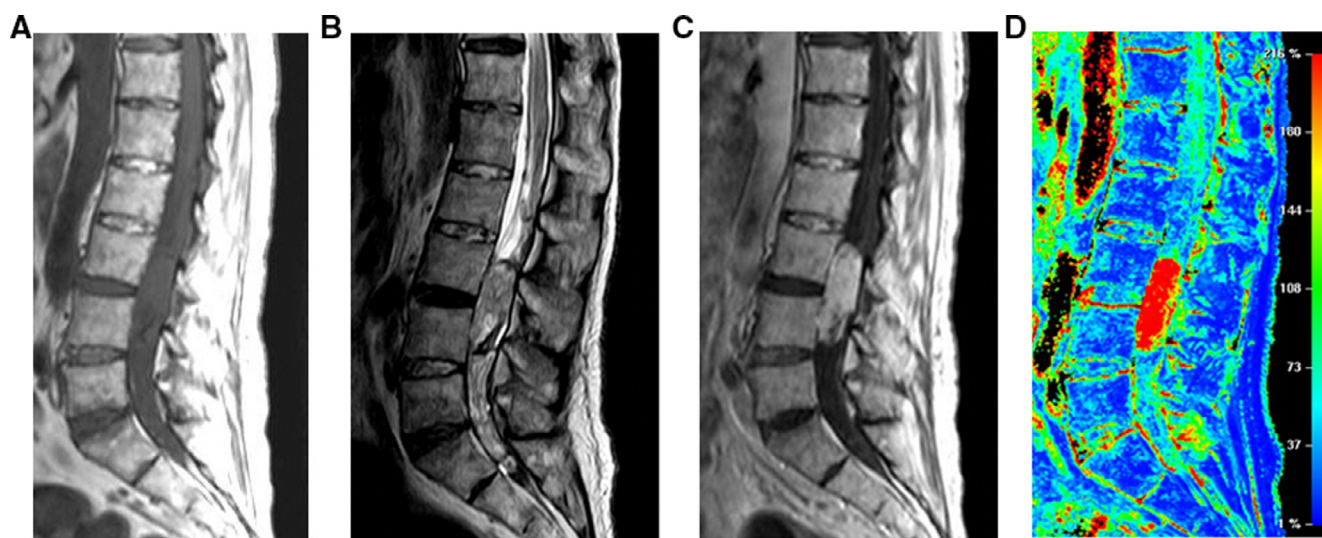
Paraganglioma of the cauda equina in a 75-year-old male. Sagittal T1-weighted (A), T2-weighted (B), gadolinium-enhanced T1-weighted (C) and, perfusion-weighted (D) magnetic resonance images revealing a large homogeneously isointense intradural lesion extending from L3 to L4, with heterogeneous enhancement after gadolinium. T2W imaging revealing a hypointense rim at the superior and inferior aspect of the lesion and flow voids cranial to the mass indicative of venous congestion or high vascularity of the tumor (B). Perfusion-weighted images showed increased rCBF in the lesion, suggesting high vascularization (D).
